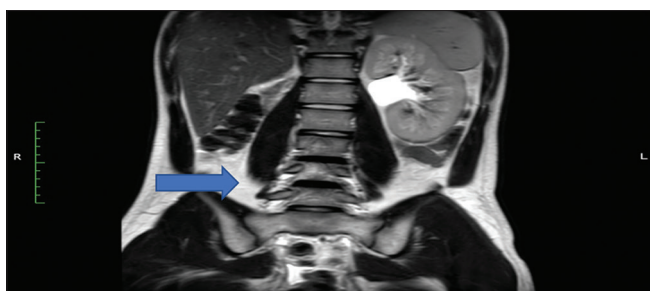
T2-weighted coronal section image showing absent right kidney
